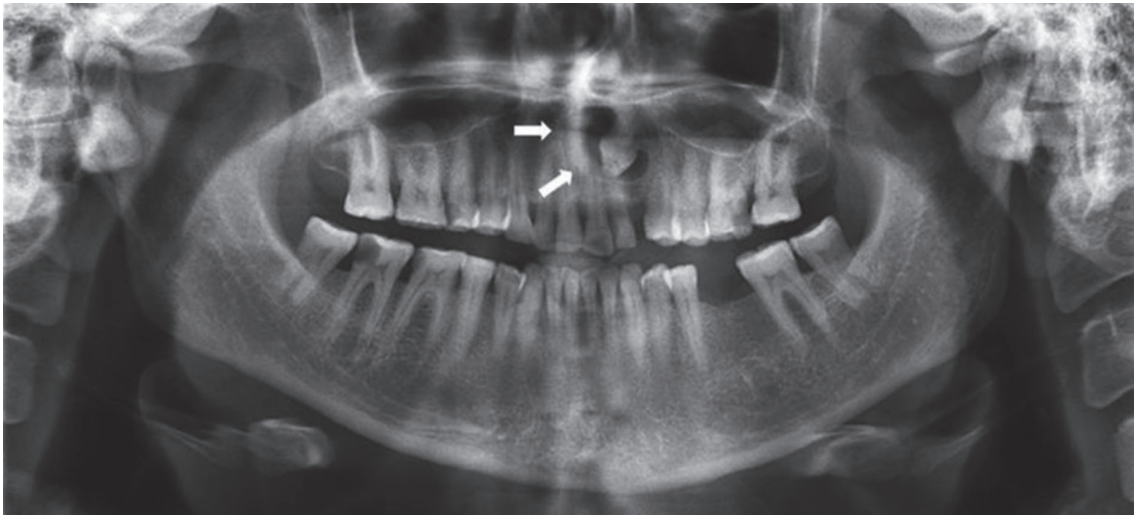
Panoramic radiograph before surgery.
